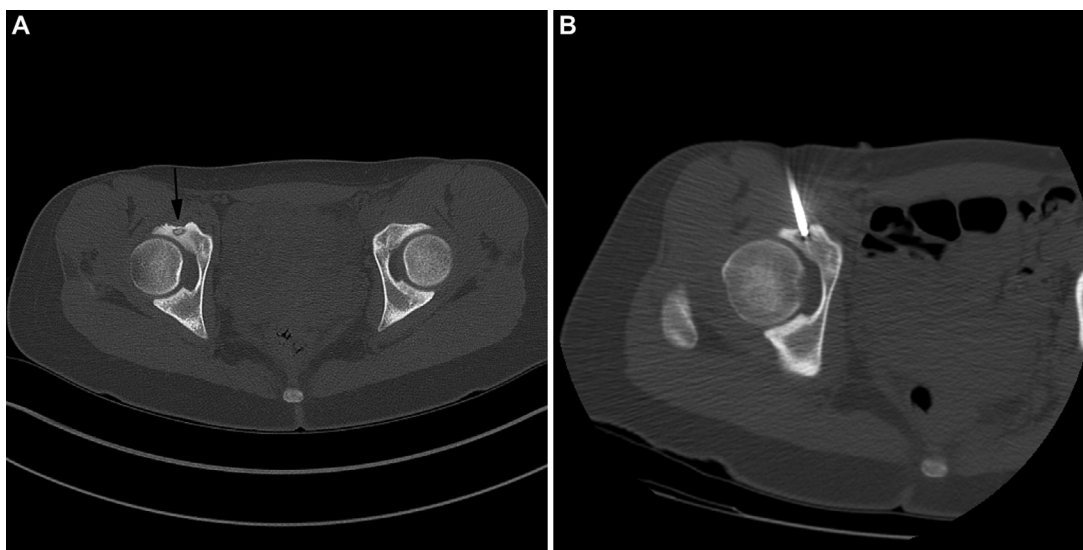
Axial CTs of the right acetabular osteoid osteoma. (A) Small lucent lesion with a central sclerotic focus and surrounding sclerosis in the right acetabulum, consistent with an osteoid osteoma. (B) Intraprocedural axial CT of subsequent radiofrequency ablation of the right acetabular osteoid osteoma.
